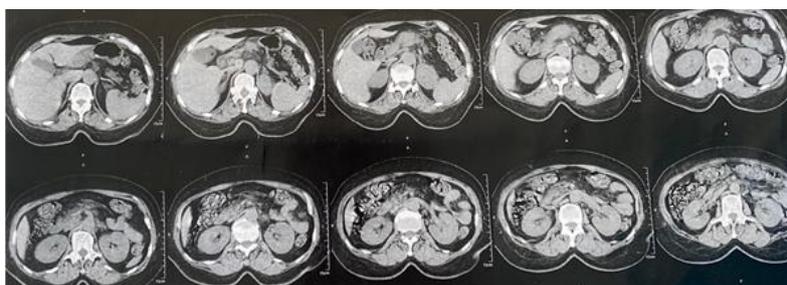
Abdominal CT scan showing tumoral enlargement of the pancreatic tail associated with infiltration of the peripancreatic fat.
